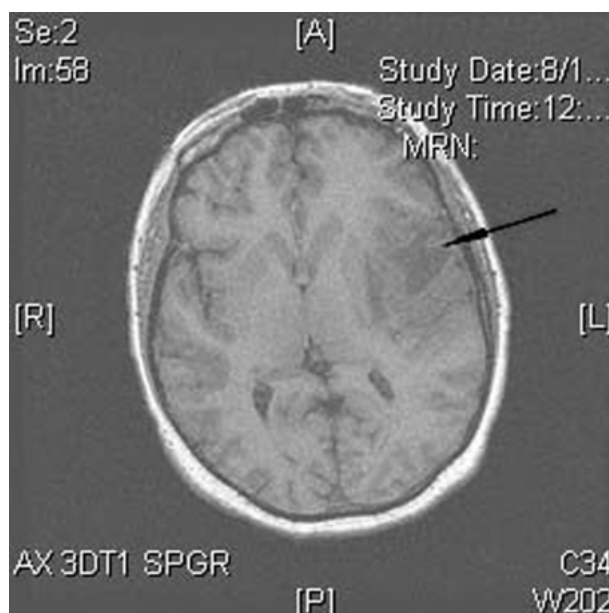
Head magnetic resonance image (MRI) of a patient who presented with dysarthria and hemiparesis. MRI revealed a left frontotemporal mass (arrow). Biopsy revealed adenocarcinoma from unknown primary. Further evaluation revealed the primary lesion to be an asymptomatic pancreatic adenocarcinoma.
